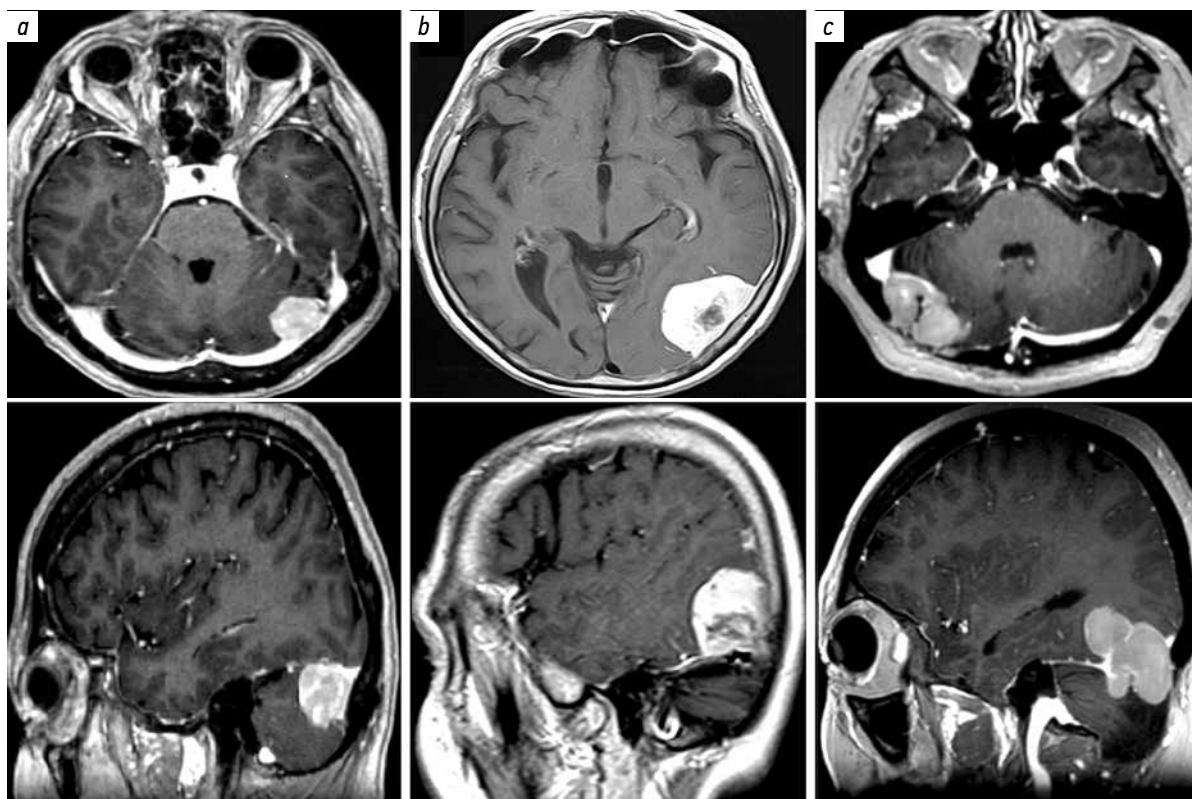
Magnetic resonance imaging. Tentorial and transverse sinus meningiomas: a – subtentorial; b – supratentorial; c – sub- and supratentorial
